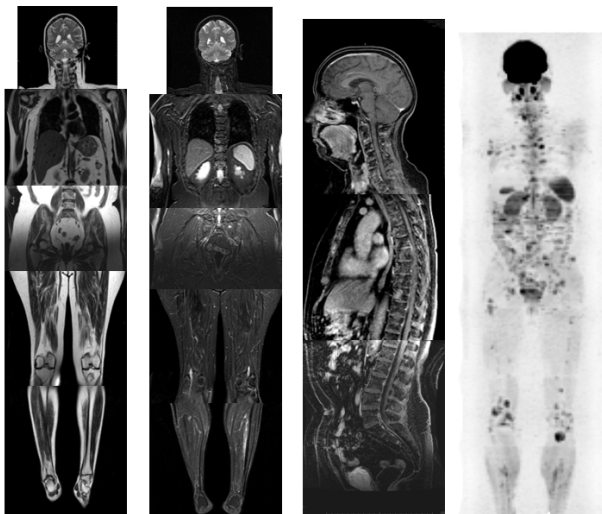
(from left to right) a) coronal fTED T2-weighted image without fat suppression. b) coronal fTED T2-weighted image with fat suppression. c) sagittal 3D FSPGR-DE post-contrast T1-weighted image with fat suppression. d) STIR-prepared diffusion weighted image.
